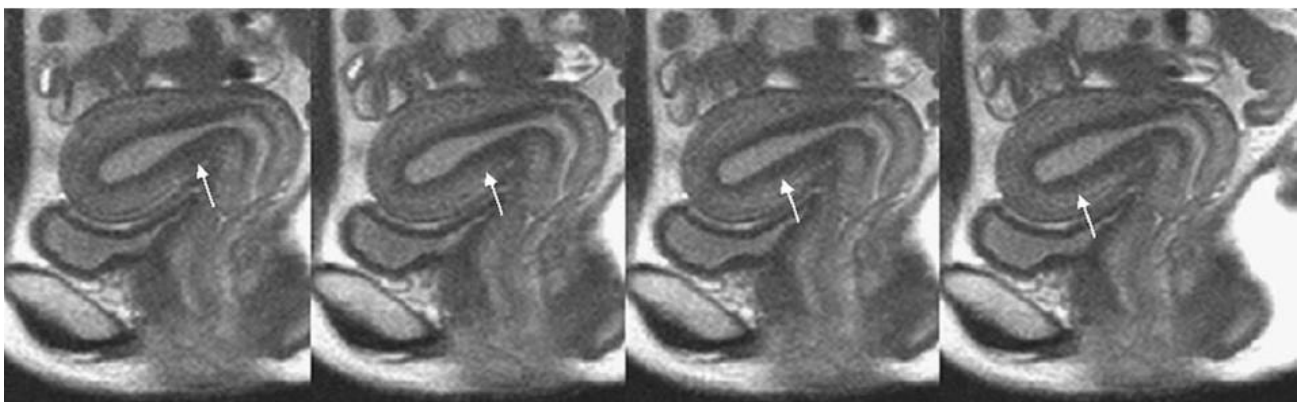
Four serial Half-Fourier Acquisition Single-Shot Turbo Spin-Echo (HASTE) magnetic resonance images of the midsagittal uterine plane of a healthy individual during the periovulatory phase [The arrow indicates a peristaltic contraction moving from the cervix to the fundus (Kido et al., 2007).]
